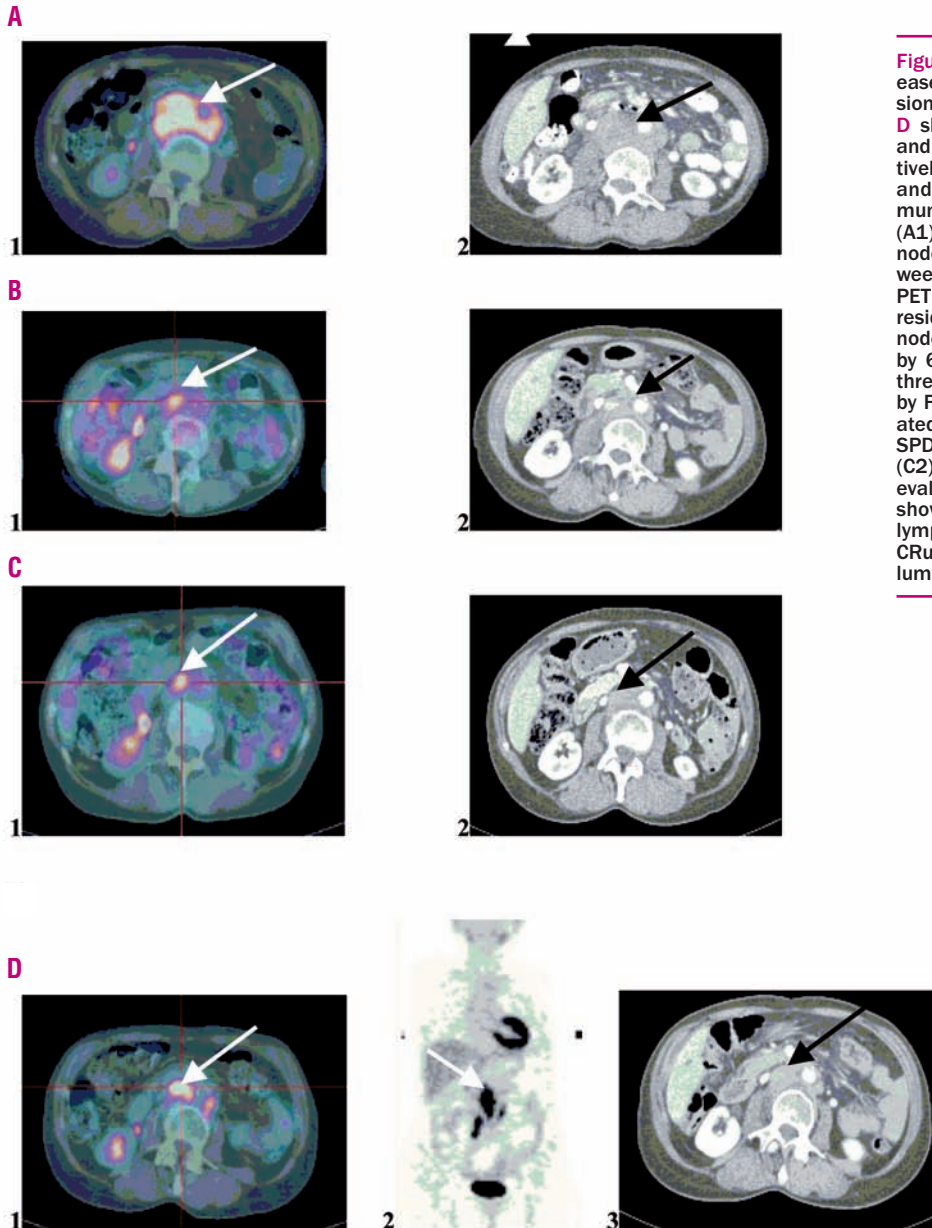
Detection of residual disease and early detection of progression by FDG-PET. Images A, B, C and D show FDG-PET and CT transverse and coronal images recorded, respectively, before RIT and six weeks, three and six months after radioimmunotherapy. Pre-treatment FDG-PET (A1) and CT (A2) show lumbar lymph node involvement. Response at six weeks was evaluated as PR by FDG-PET and CT (B1 and B2 arrows show residual masses in lumbar lymph node). The lesion has been reduced by 65% on CT images. Response at three months was evaluated as PR by FDG-PET (C1), while CT was evaluated as CRu with a reduction of the SPD of 80% compared with baseline (C2). FDG-PET at six months was evaluated as PD (D1 and D2: arrows show increase of size of lumbar lymph nodes), while CT confirmed CRu with a reduction of 84% of the lumbar mass (D3).
